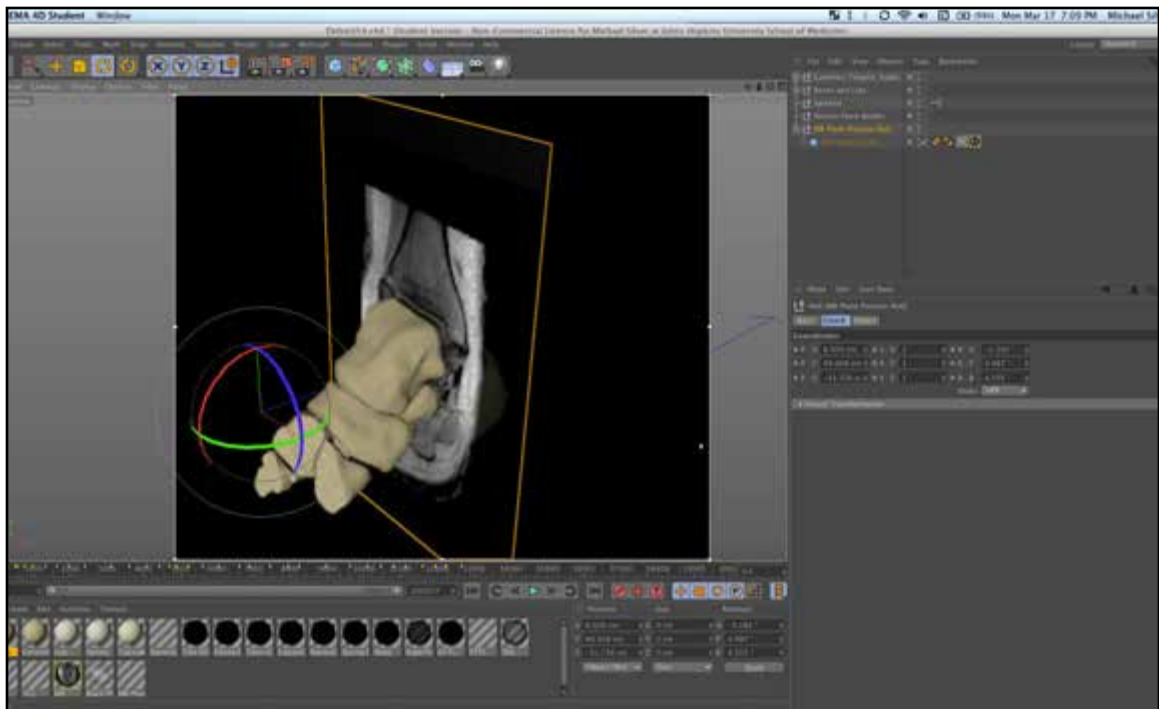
Using MR alignment null to position MR plane by matching MR image to bone mesh.
